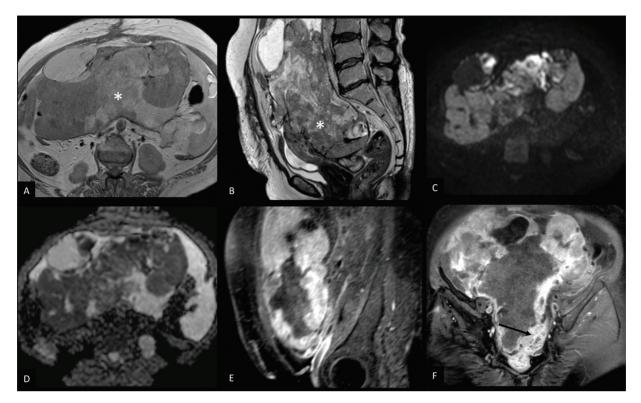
Contrast enhanced MRI of leiomyosarcoma of uterus (stage IV A). T1 axial (A) and T2 sagittal (B) images show a large, ill-defined, heterogeneous lesion (\*) replacing the entire uterus and involving bilateral adnexa, reaching up to the bilateral pelvic side walls. DWI (C) and corresponding ADC map (D) show areas of diffusion restriction. Post contrast sagittal (E) and coronal (F) images show heterogeneous enhancement of the mass and infiltration of the rectum (arrow in F).
